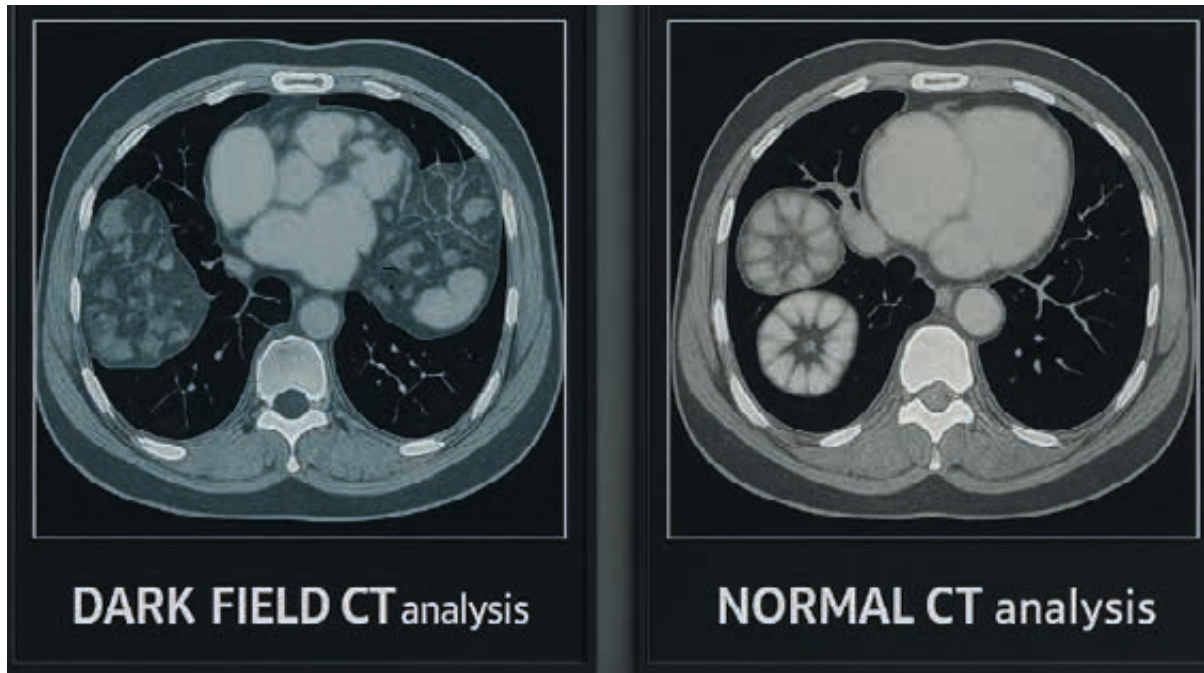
A creation by DALL-E from ChatGPT, showing a prediction of how DFCT (left) would look when compared to conventional CT (right). The DFCT shows finer lung markings, clearer differentiation between cortical and trabecular bone in the vertebral body, and sharper delineation of paraspinal muscles and other soft tissues.
